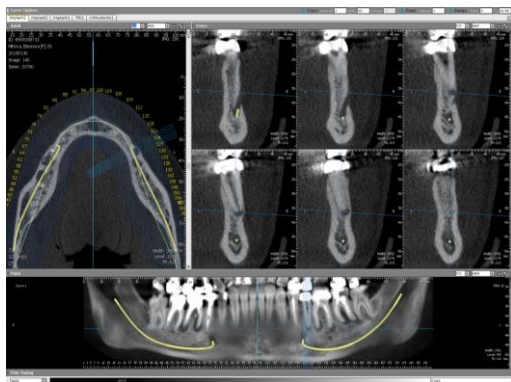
CBCT to confirm the diagnosis
